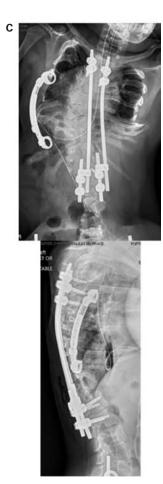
(A) AP and Lateral radiographs prior to halo-gravity traction; (B) Patient attending school virtually while in halo-gravity traction; (C) Post-operative AP and Lateral radiographs following growing rod insertion.
